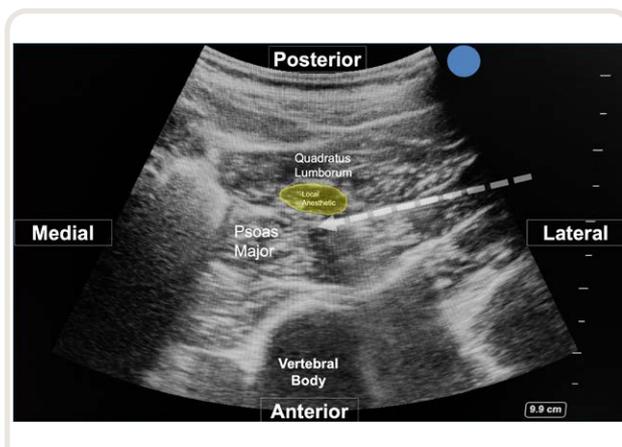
Ultrasound image of anterior quadratus lumborum block. The hashed arrow indicates needle placement. The local anesthesia is injected anterior to the quadratus lumborum muscle with an endpoint demonstrating a fusiform separation of the local anesthesia in the fascial plane between the quadratus lumborum muscle and the psoas major muscle.
